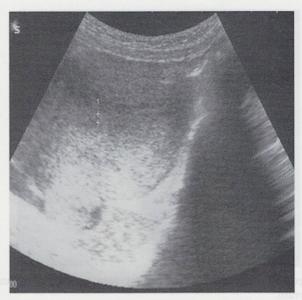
Transabdominal ultrasound of the uterus after drainage of hematometra.
